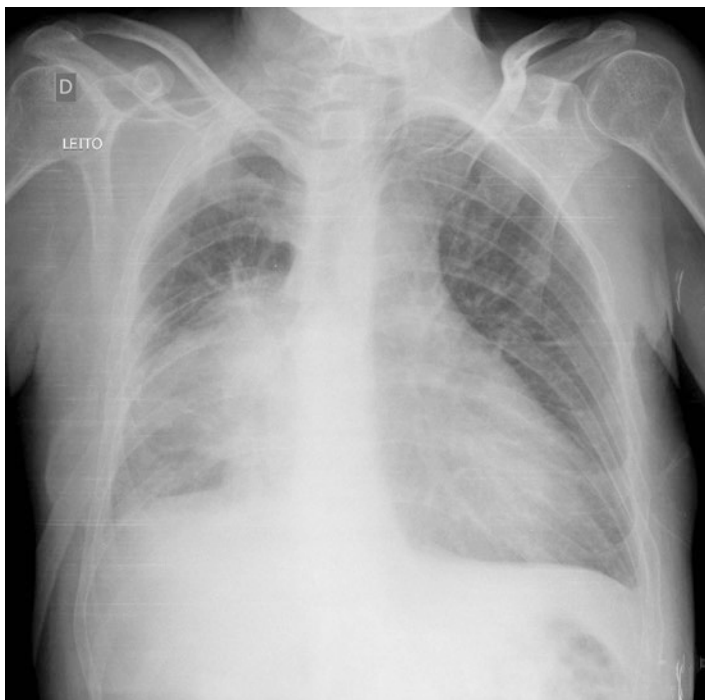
Chest x-ray just before pericardiocentesis
